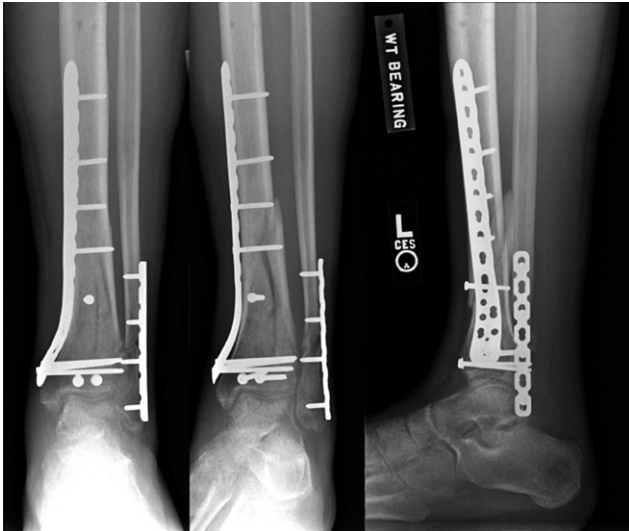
Same patient as Figures 5 and 6. Weight-bearing radiographs reveal anatomic alignment with percutaneously placed medial plate. Note that percutaneously periarticular screws were used to reduce the articular component. The plate is placed after the plafond is anatomically reduced. The fibula was concomitantly repaired with standard techniques.
